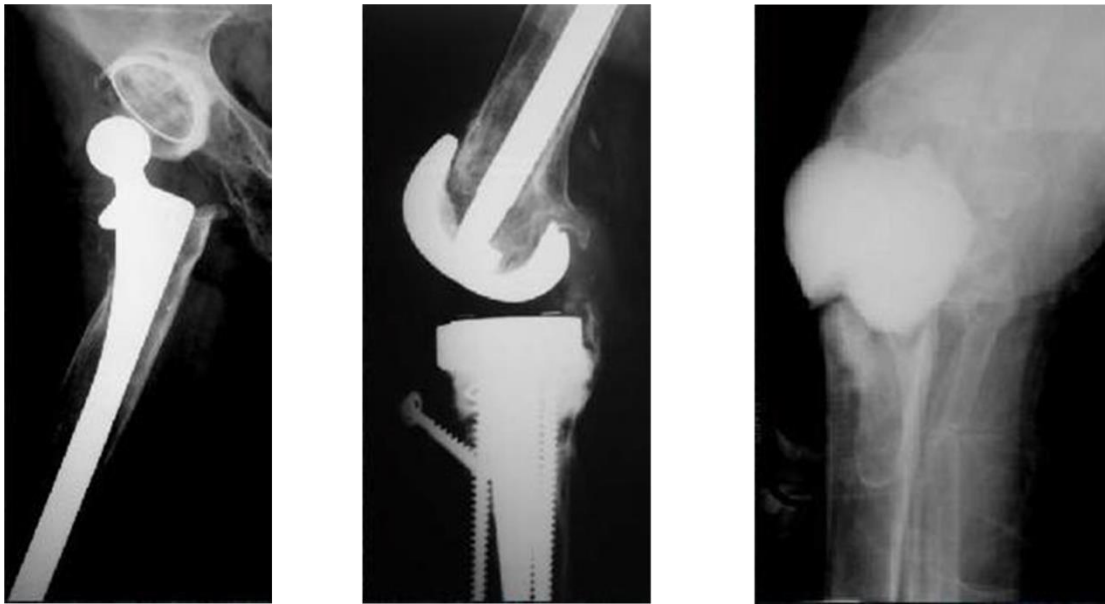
A: X-ray of showing the total hip replacement with the long stem and cemented acetabulum with dislocation of the right hip
